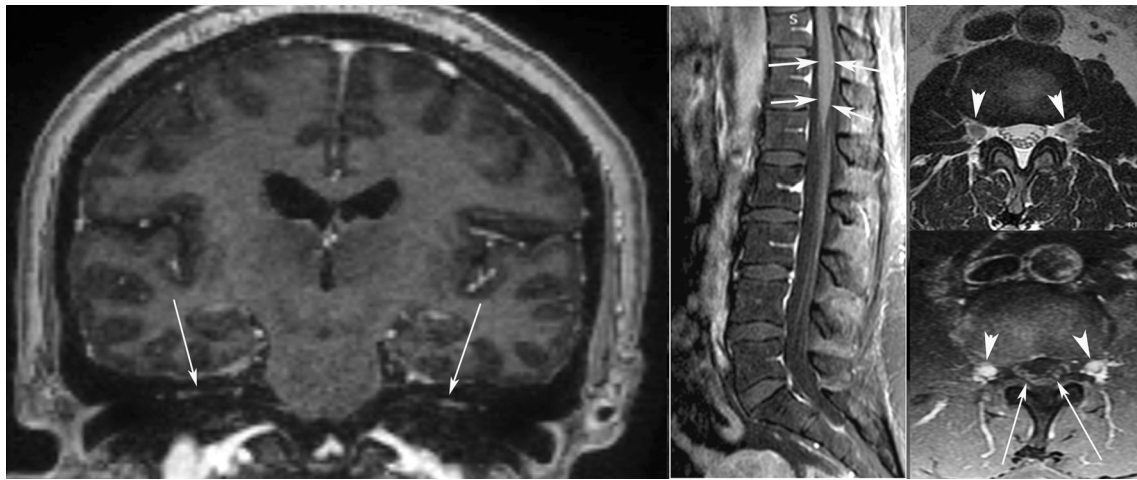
Diagnostic MRI. a Coronal brain T1 MRI with gadolinium contrast (Gd) images showing bilateral facial nerve enhancement (arrows). b Sagittal lumbar spine T1 MRI with Gd showing enhancement in the medullary cone (arrow). c Axial lumbar-spine T2
